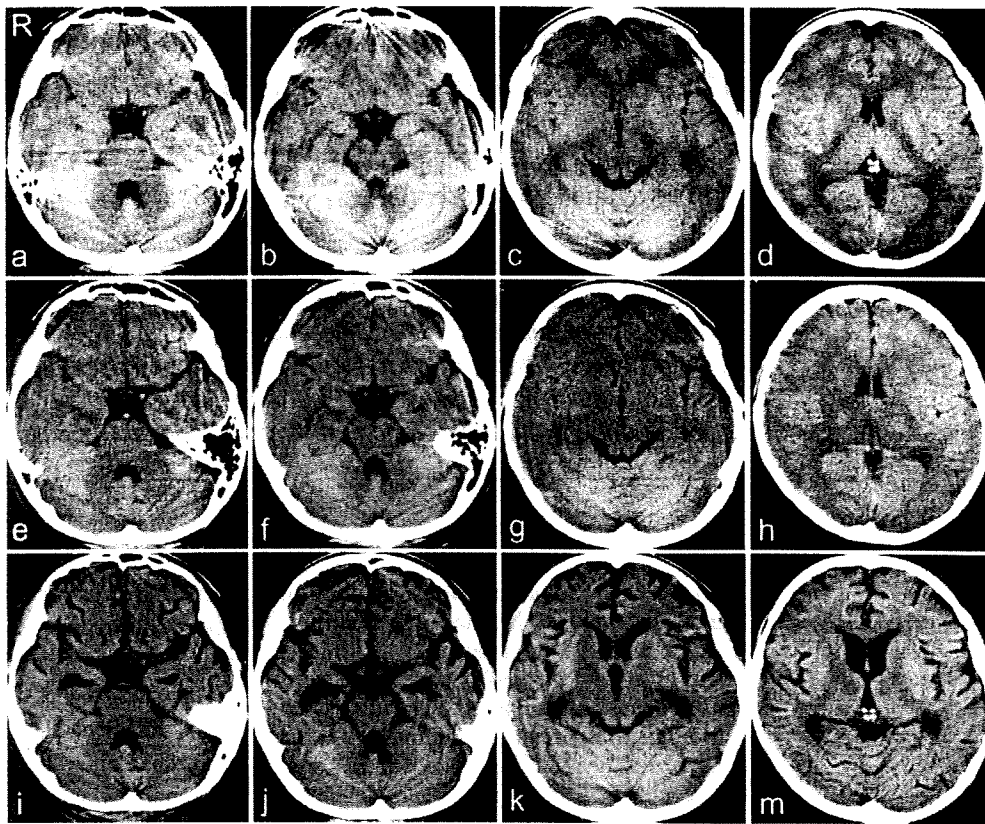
a,b,c,d: Brain CT on admission was within normal limits. e,f,g,h: Brain CT 10 days after onset demonstrated hypodensities in the right hippocampus (e, f), and outlines of the basal ganglia and thalamus were unclear, suggesting edematous changes (g,h). Brain CT obtained 1 day before death disclosed whole brain atrophy and enlargement of the inferior horn of the lateral ventricle with right predominance (i, j). Hypodensities were seen in the anterior portion of the bilateral thalamus (m).
